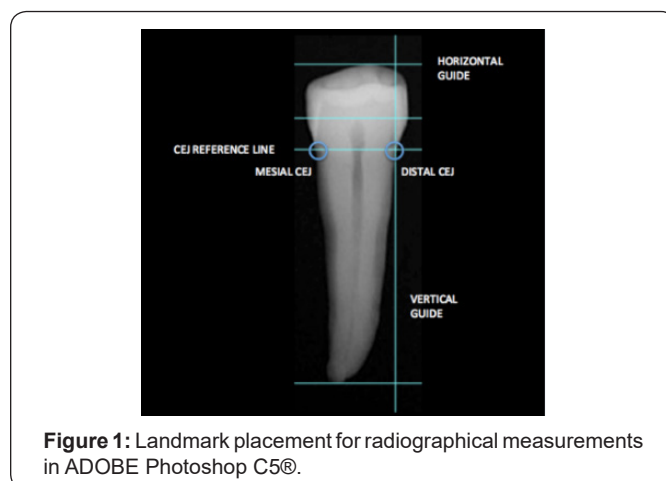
Landmark placement for radiographical measurements in ADOBE Photoshop C5®.
